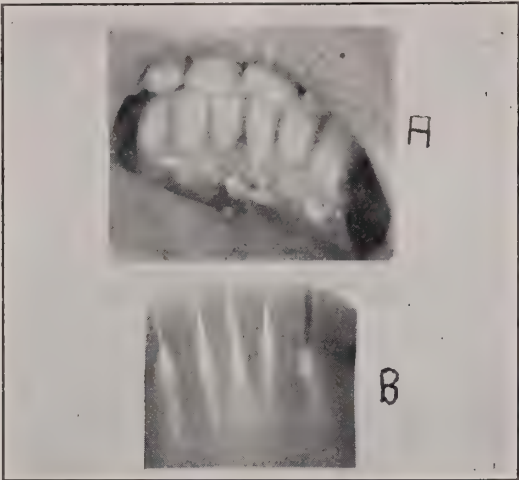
(a) Destruction of soft tissue about an incisor tooth. (b) Radiograph of same tooth fails to show presence of the disease, because the bone destroyed by the lesion is over-shadowed by the tooth.
